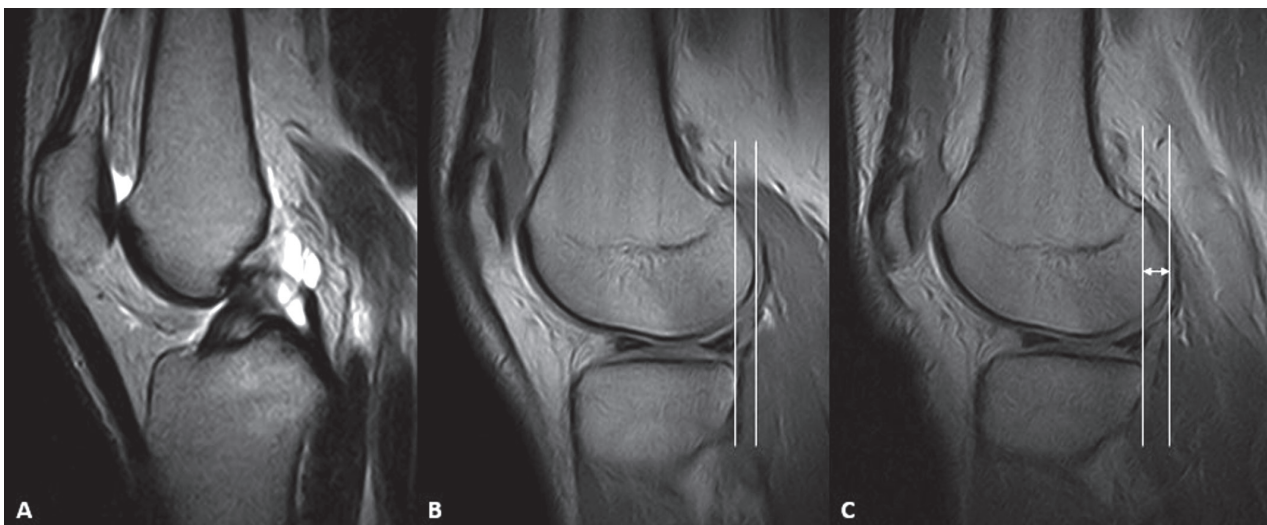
Sagittal MRI images of the knee of a patient with ACL rupture in standard supine (A, B) and weight bearing position (C): we can appreciate the anterior tibial translation (red arrows), as a sign of ACL insufficiency under load condition
